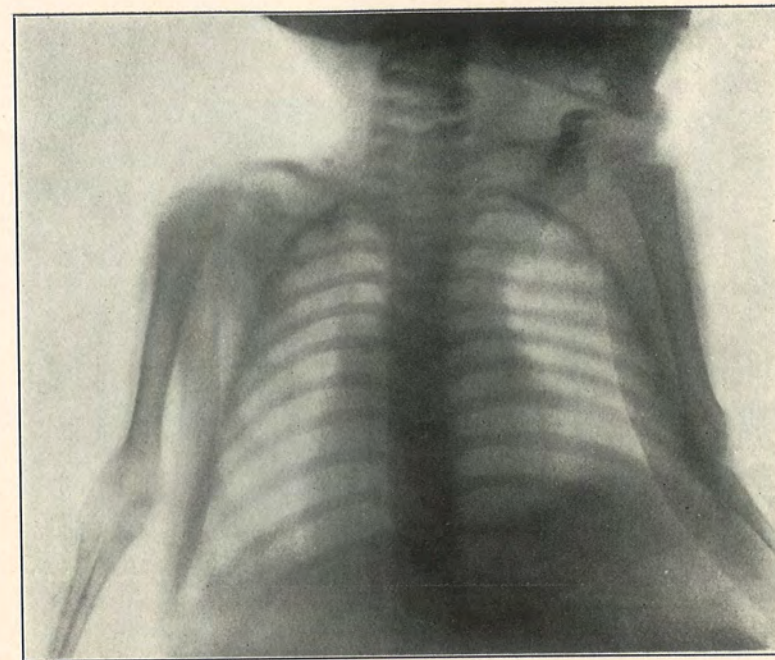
Case I, Congenital elevation of scapula. (Radiograph by C. L. Leonard, M.D.)
